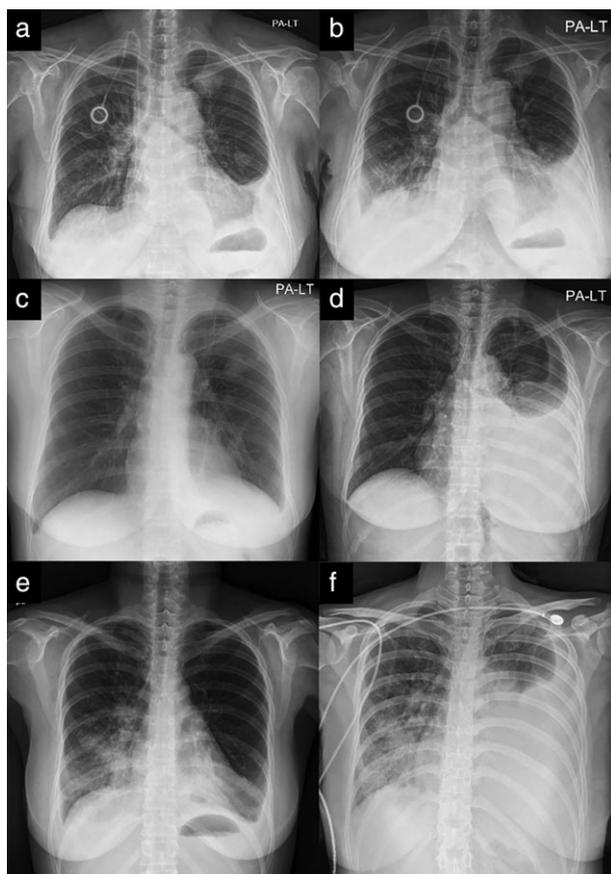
Changes on chest radiography in three patients who discontinued treatment as a result of serious adverse events. Patient #1: (a) pre-treatment and (b) after two weeks of treatment. Patient #2: (c) pre-treatment and (d) after two weeks of treatment. Patient #3: (e) pre-treatment and (f) after one week of treatment.
